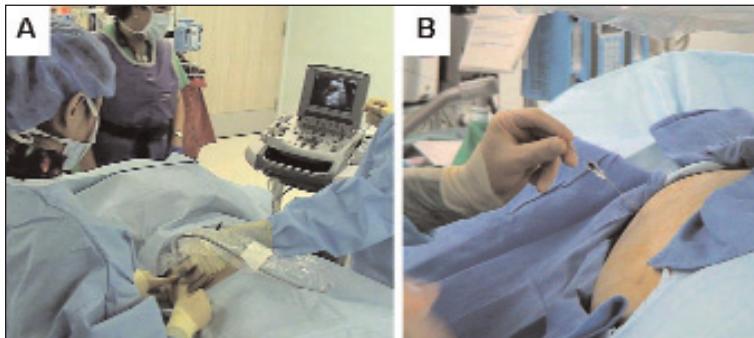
A transhepatic ultrasound was used to identify the portal vein (A), which was accessed using a .014-inch micropuncture entry needle (B).
